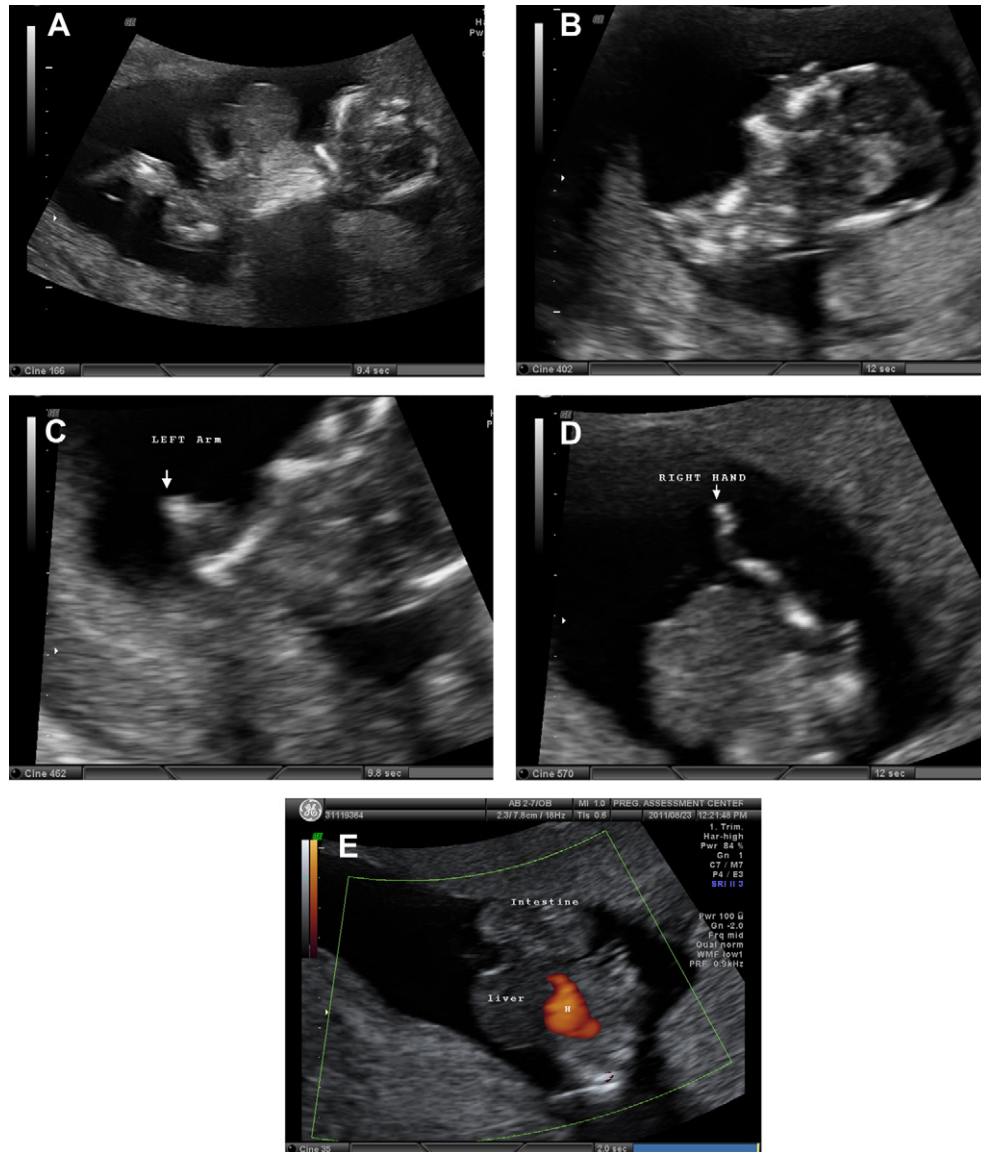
Prenatal ultrasound at 13 weeks of gestation shows (A) a deformed skull with cranioplacental attachment, eviscerated solid and hollow internal organs, and upper limb deficiency, (B) nasal deformation, (C) left arm deficiency, (D) right arm hypoplasia with absence of the hand, and (E) extracorporeal liver and intestines. H = heart.
